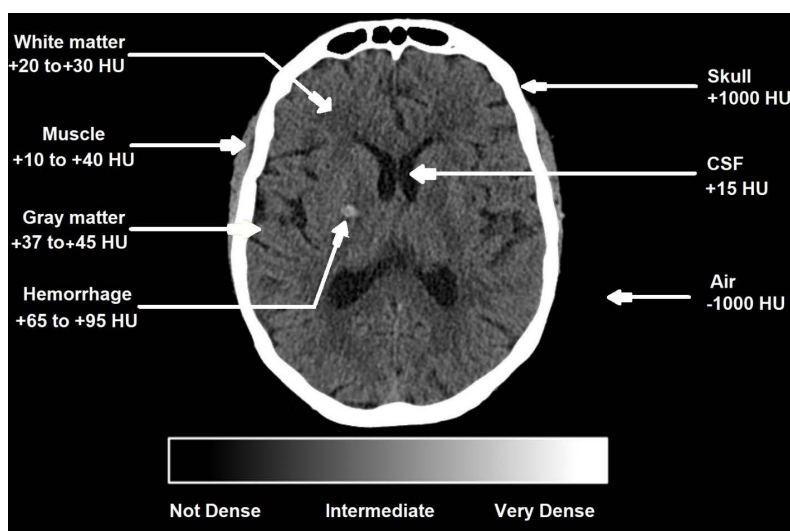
Hounsfield units and CT number integers.
